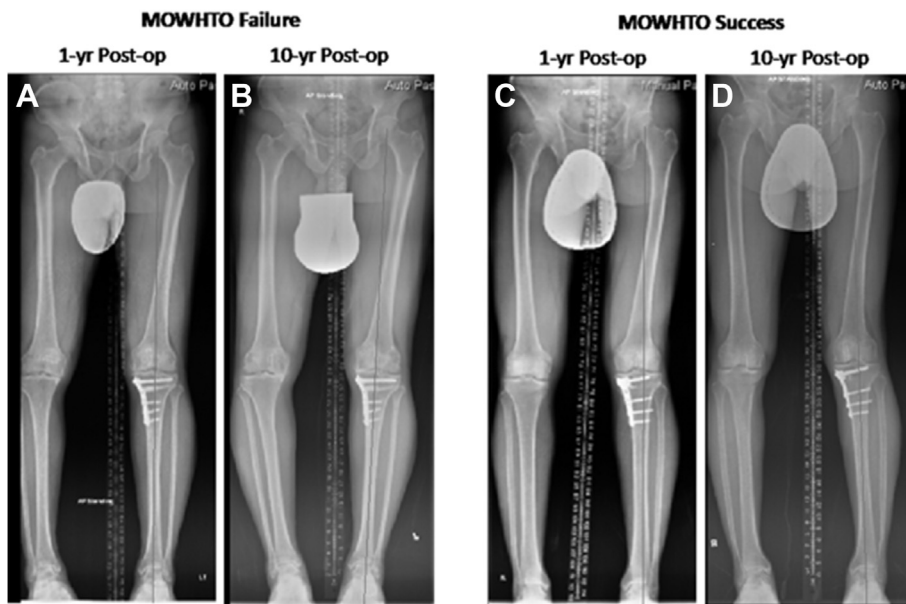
Long leg standing anteroposterior (AP) radiographs at 1-year and 10-years after MOWHTO. (A) MOWHTO failure correlated with neutral alignment at 1-year postop radiograph. (B) MOWHTO failure at 10-year postop showing progressive varus deformity and medial compartmental osteoarthritic changes. (C) MOWHTO success significantly correlated with valgus alignment at 1-year postop. (D) MOWHTO success at 10-year postop showing preservation of alignment, medial and lateral compartmental joint spaces. MOWHTO = medial open-wedge high tibial osteotomy.
